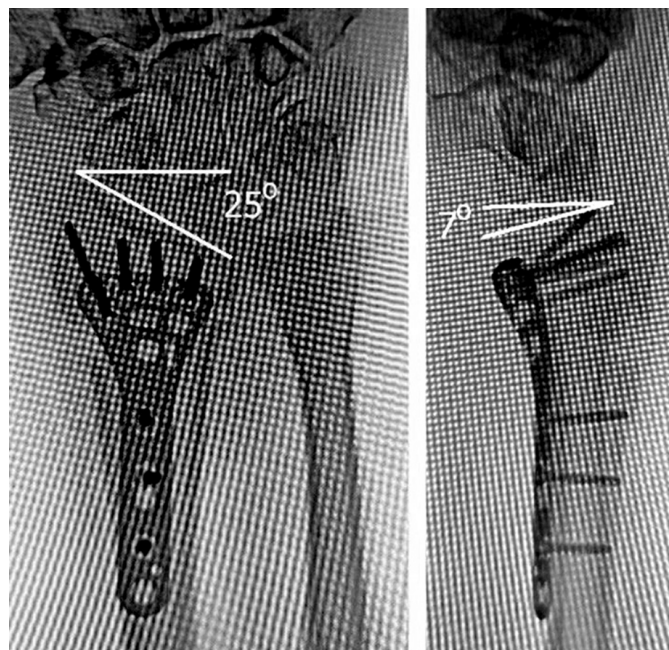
Radiographs of the right wrist joint after surgery: correct relationships of the articular surfaces and the length of the forearm bones have been restored
